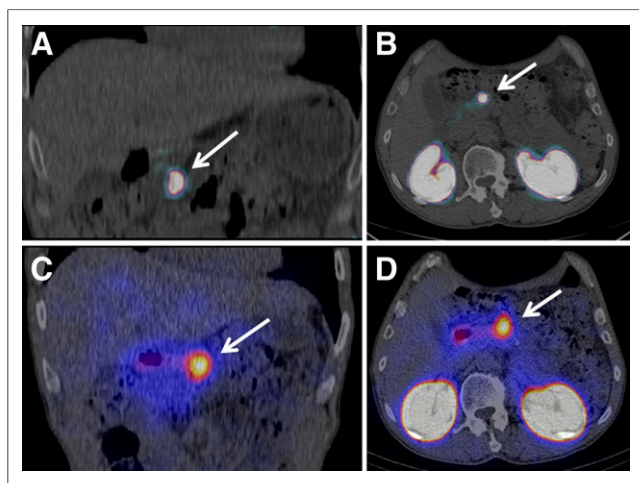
(A and B) Coronal (A) and transaxial (B) PET/CT images from patient 4 obtained 2.5 h after injection of 80 MBq of ⁶⁸Ga-DOTA-exendin-4. (C and D) Coronal (C) and transaxial (D) SPECT/CT images of same patient 72 h after injection of 90 MBq of ¹¹¹In-DOTA-exendin-4. Focal uptake of ¹¹¹In-DOTA-exendin-4 and ⁶⁸Ga-DOTA-exendin-4 is seen in pancreatic body (arrows); patient has refused surgery so far.
